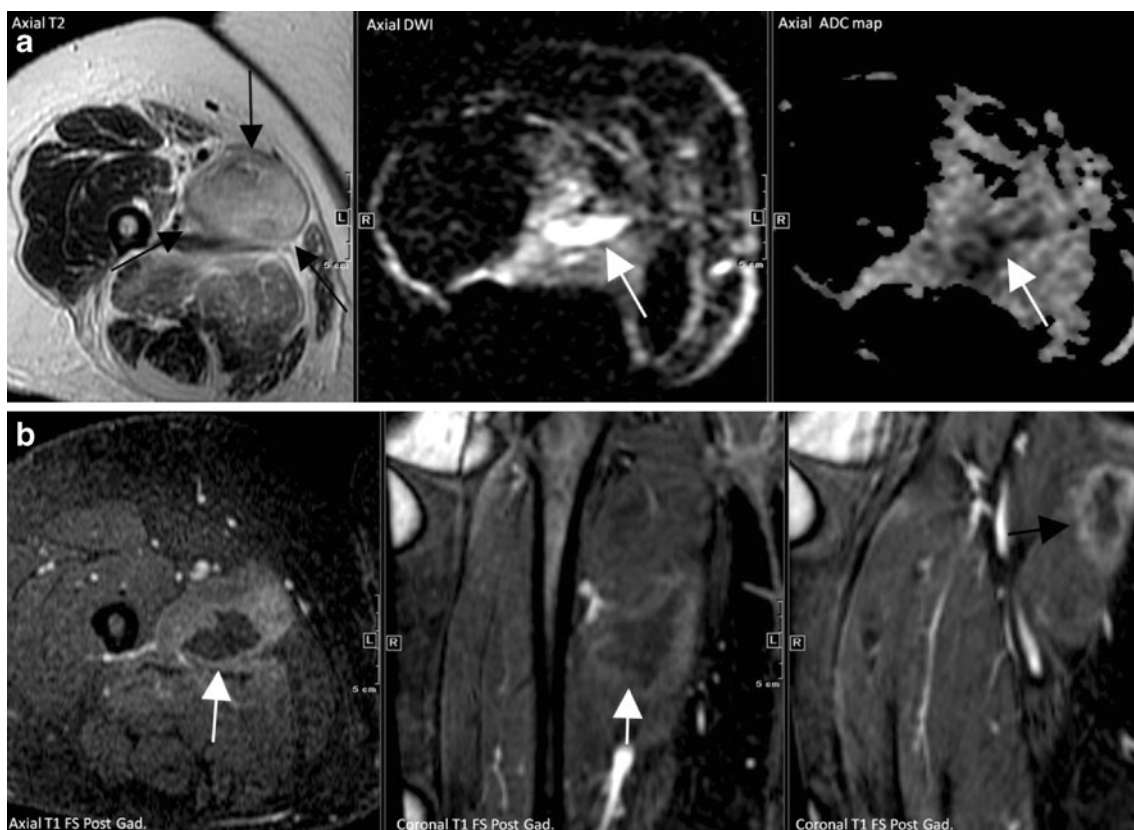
a (Case 5): Axial T2-weighted MR image shows marked edema in the adductor muscles (*black arrows*). There is a DWI bright (*white arrow*) and ADC dark (*white arrow*) focus within the muscle in keeping with restricted diffusion. b (Case 5): Axial and coronal post-contrast MR images demonstrate peripheral enhancement (*white*
